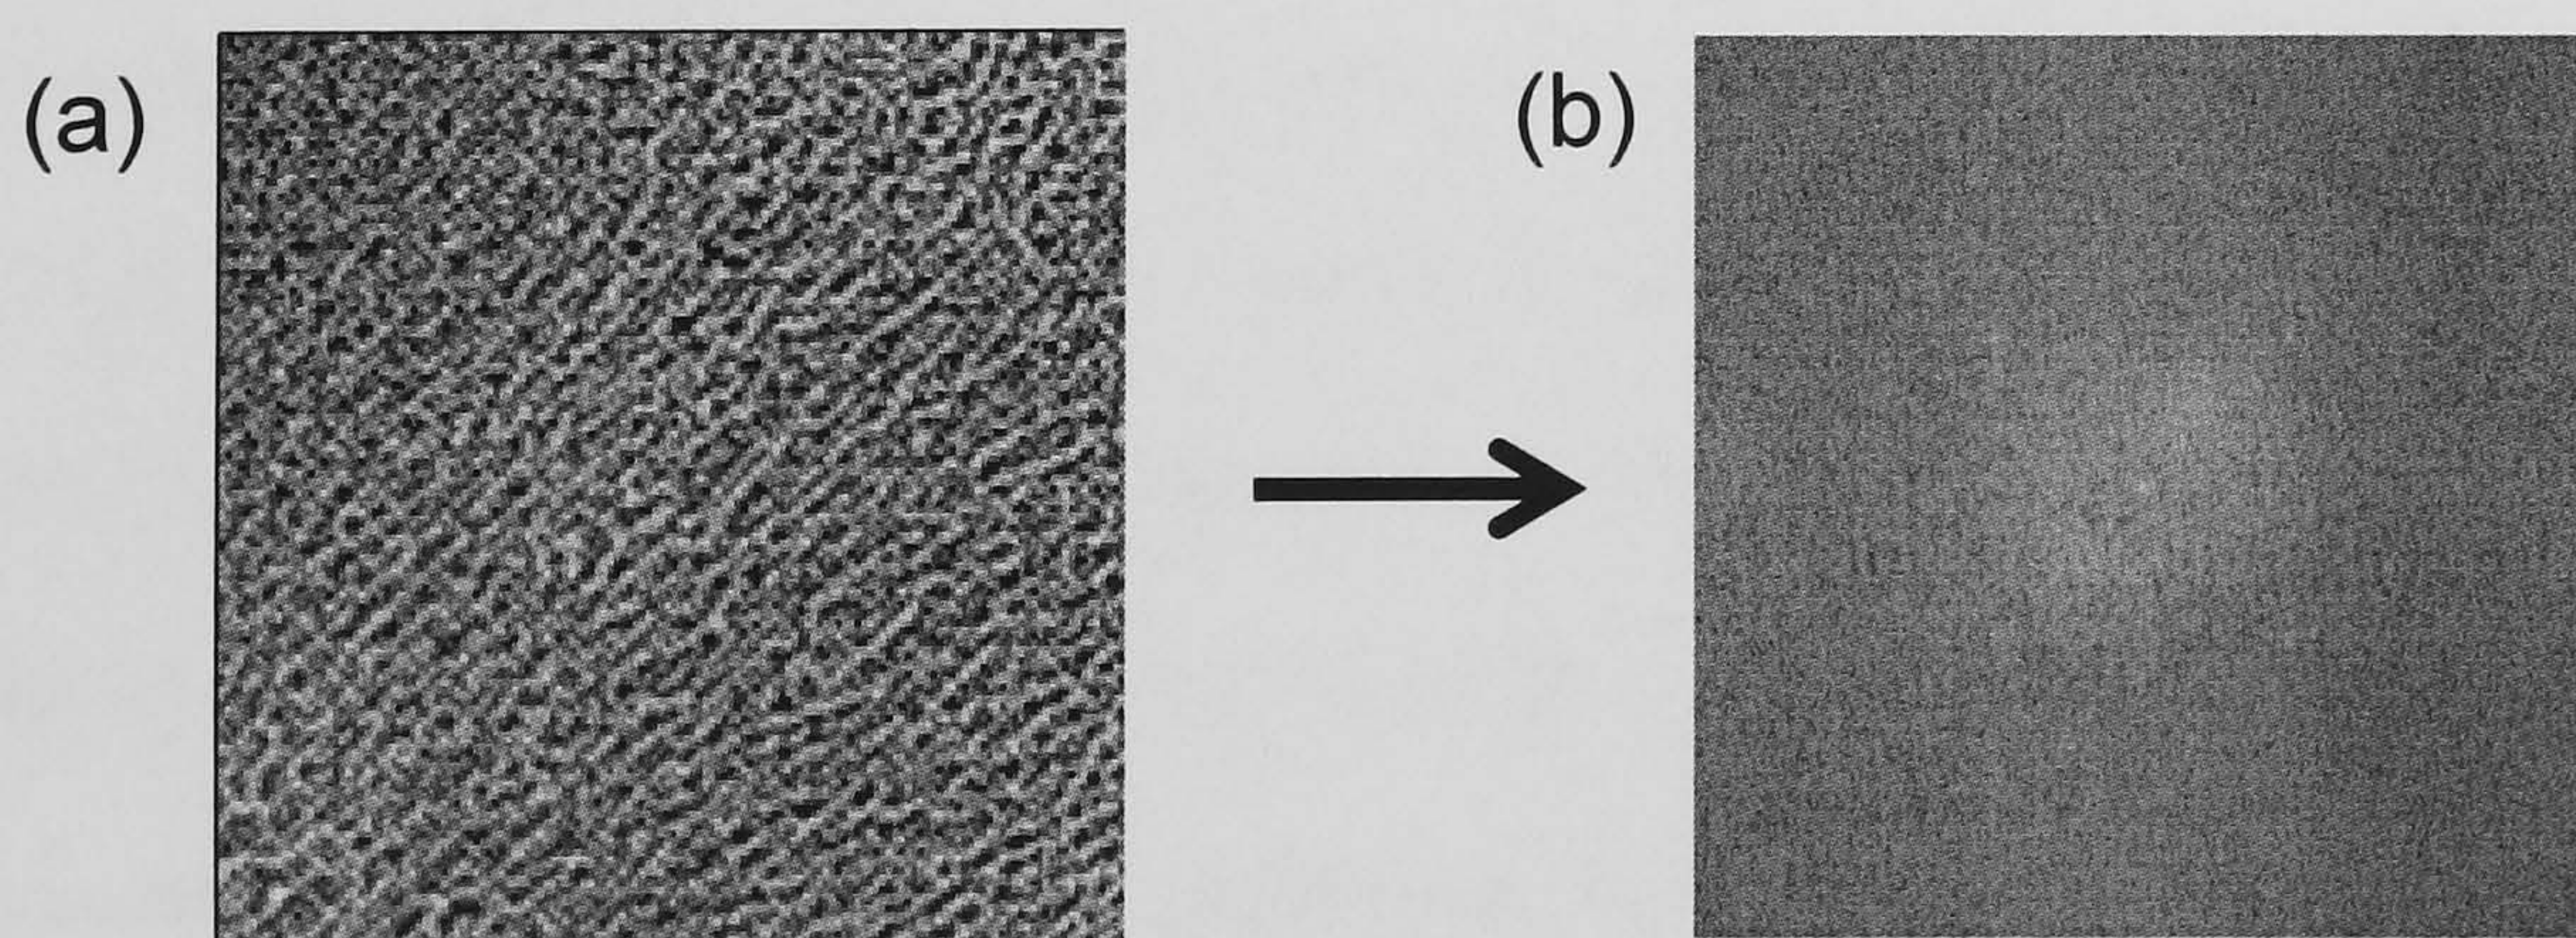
The Fast Fourier transform. (a) a radiographic image or μ CT section can be transformed into (b) a secondary image using the Fast Fourier transform technique. If the original image is anisotropic the transform reveals this.
